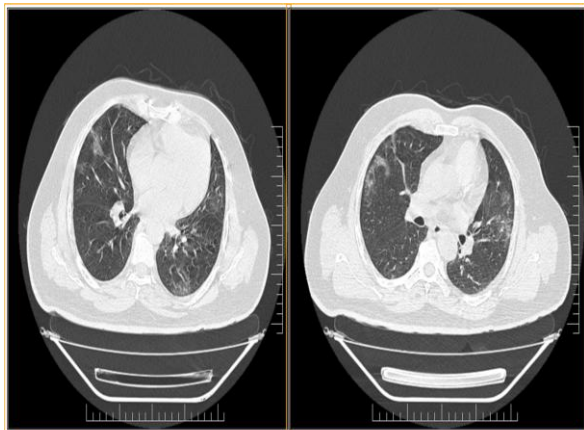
Axial section through CT chest of a 34 year old male patient show peripheral ground glass opacities in bilateral upper and middle lobes
